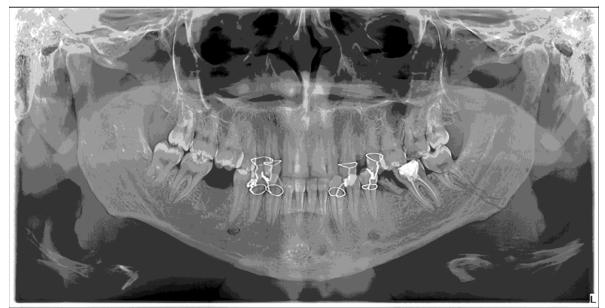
Radiography of one of the included cases in which the treatment option was the extraction of the lower left third molar in order to proceed with the proper treatment of the mandibular angle fracture
